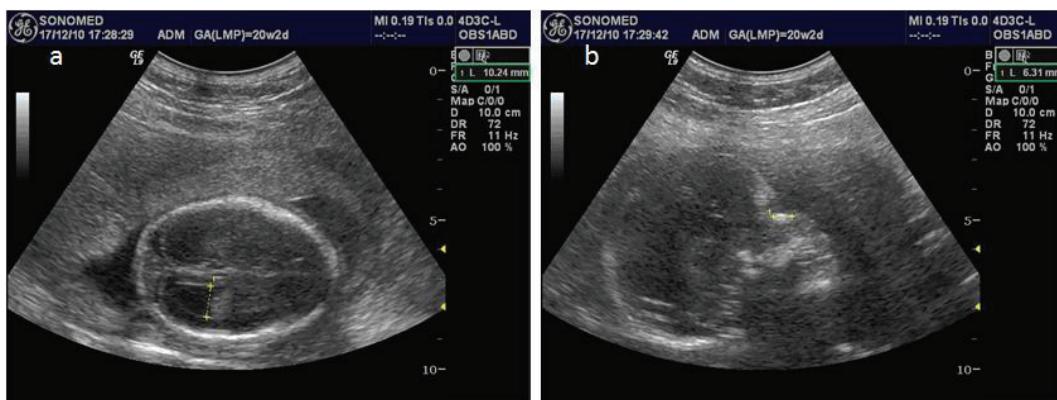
a. A representative picture of bilateral ventriculomegaly. b. Frontal bossing detected by ultrasonography.
